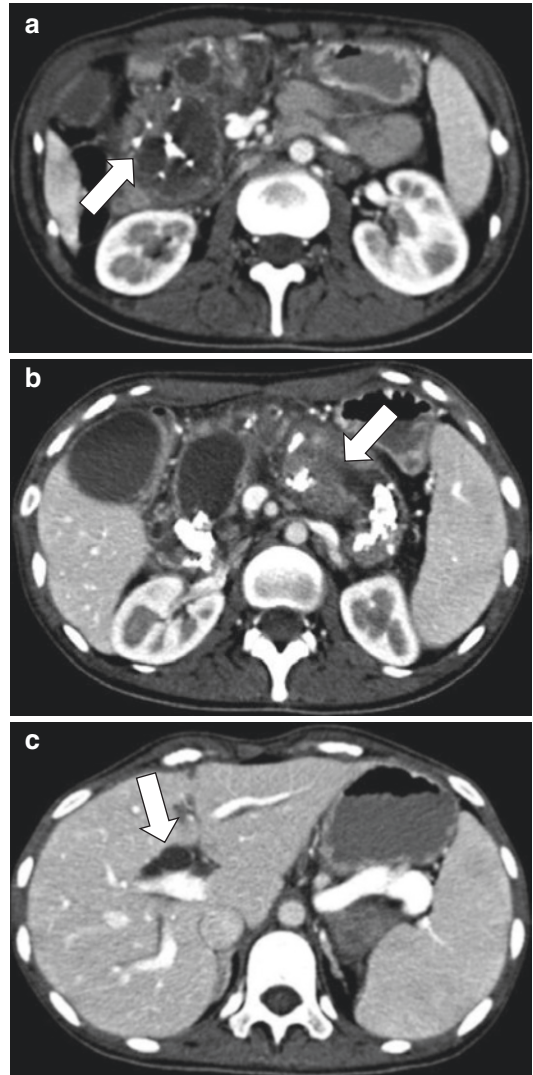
Malignant transformation of chronic pancreatitis on CT. CECT axial (a) image shows extensive intraductal calcification and atrophy of the pancreatic parenchyma suggest chronic pancreatitis. An ill-defined low-density mass (arrows) adjacent to the pancreatic body (arrow) is seen on axial (b) image. CECT axial (c) image shows Double-duct sign is clearly seen with multiple intraductal calcification (arrows) in the dilated pancreatic duct (arrowheads)
